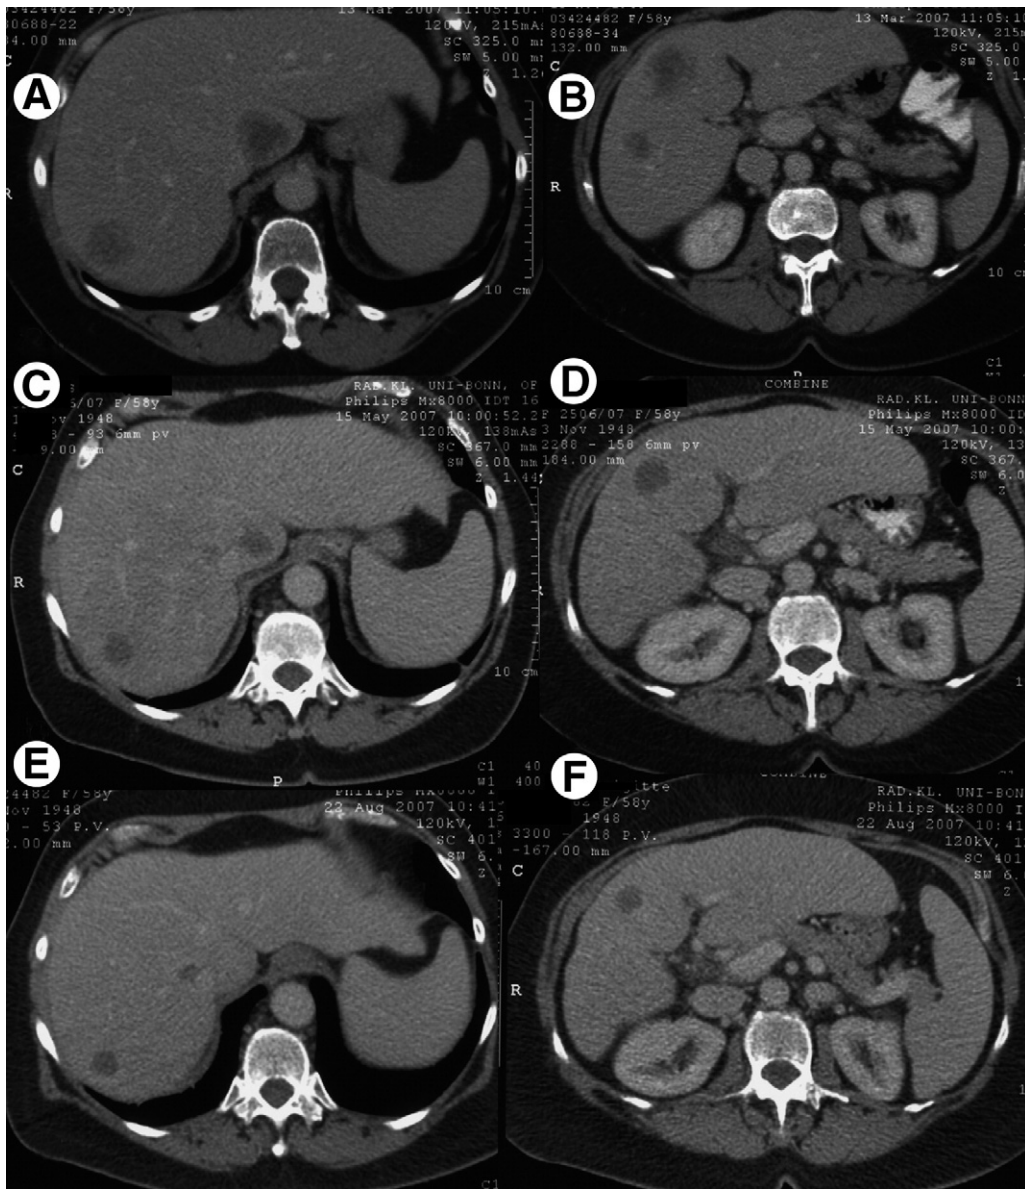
Therapy control with CT in a patient with hepatic metastases of CRC before, 2 and 5 months after whole liver SIRT depicting a clear response that was accompanied by normalization of tumor markers. (A, C) Coronal CT before SIRT. (B, D) Coronal CT 2 months after SIRT, (E, F) coronal CT 5 months after SIRT.
